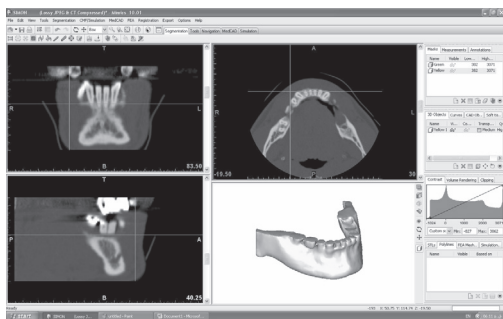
CT data processing.
